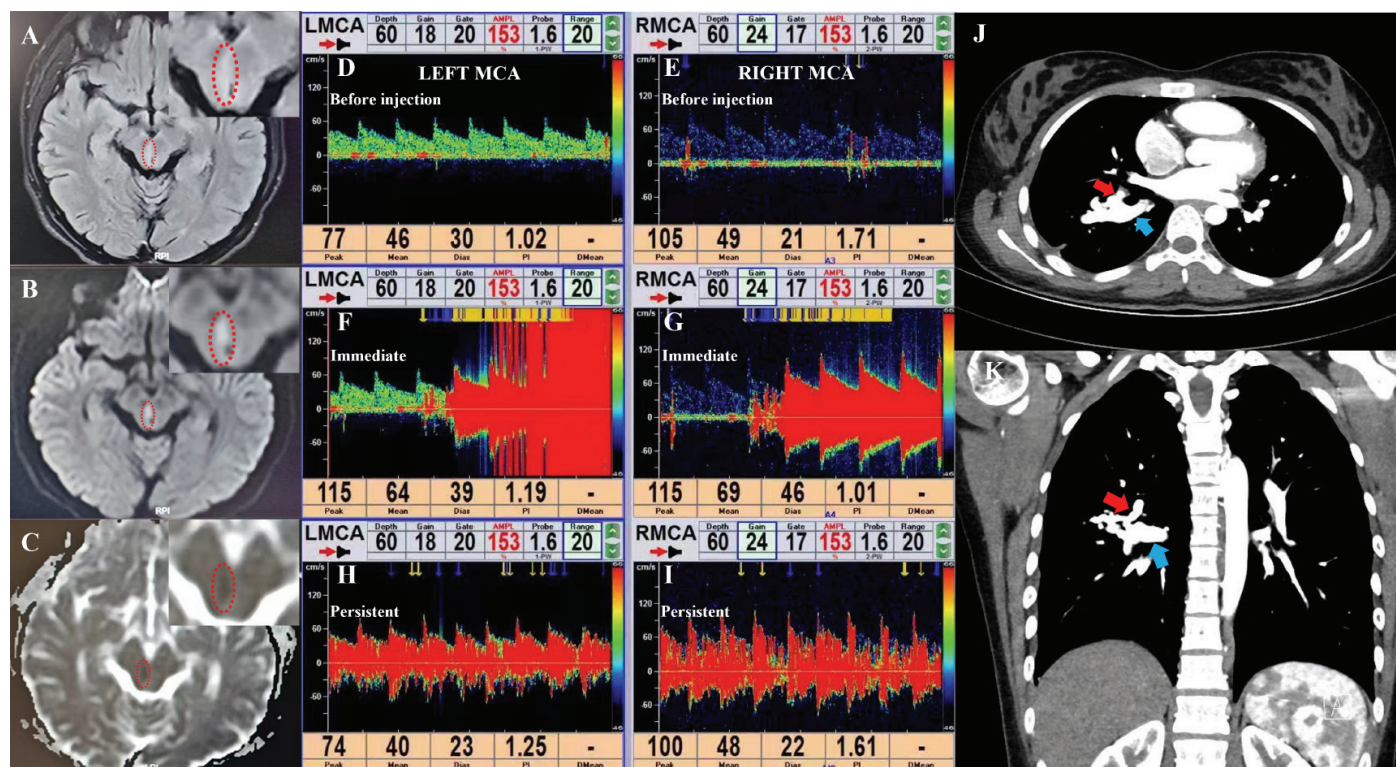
Brain MRI, c-TCD, and CT angiography. (a-c) Brain MRI of a right periaqueductal acute infarct (outlined by red dashed lines; magnified views in insets). Signal characteristics: subtle hyperintensity on fluid-attenuated inversion recovery (a), hyperintensity on diffusion-weighted imaging (b), and hypointensity on ADC (c). (d-i). Bilateral MCA c-TCD waveforms at baseline (d, e), immediately after (f, g), and persistently after contrast injection at rest (h, i), showing an immediate and persistent “curtain-like” microbubble pattern. (j, k) CT angiography confirms a right lower lobe pulmonary arteriovenous malformation, showing early contrast filling within the malformation (red arrow) and dilated draining pulmonary veins (blue arrow). MRI, magnetic resonance imaging; CT, computed tomography; c-TCD, contrast-enhanced transcranial Doppler.
